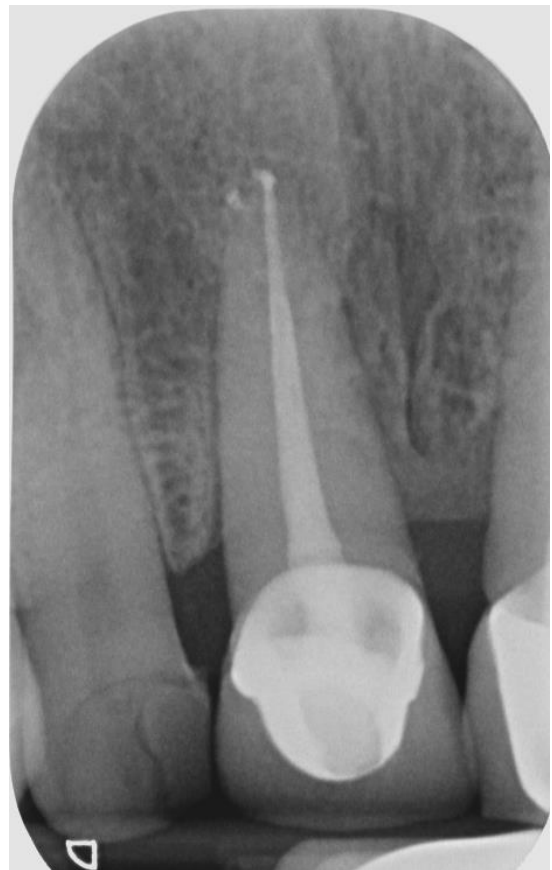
Final obturation radiograph. System B™ Endodontic Heat Source used to condense gutta percha 6mm short of the working length. HotShot obturation device used to fill remaining canal space. Well-condensed obturation, within 2mm of radiographic apex, tubuliseal extruded through apex and lateral canal
